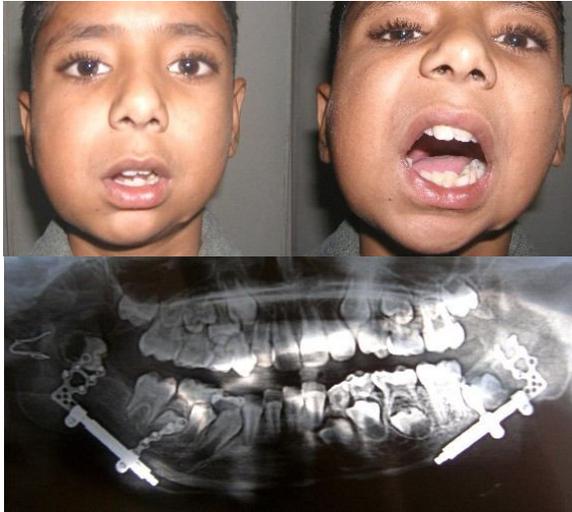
Post-distraction extraoral frontal view and orthopantomogram
